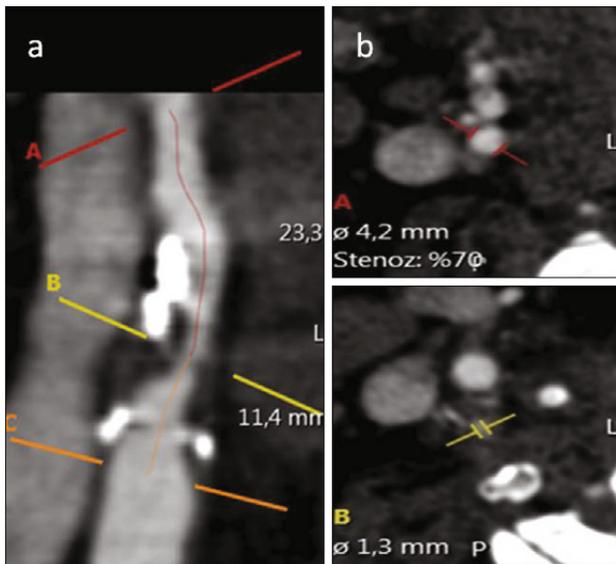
a) In the MPR vessel analysis, CTA clearly depicts the right ICA cervical stenosis at level B, b) according to stenosis analysis axial sections show that stenosis rate was calculated 70 % compared to distal normal ICA segment (level A).
